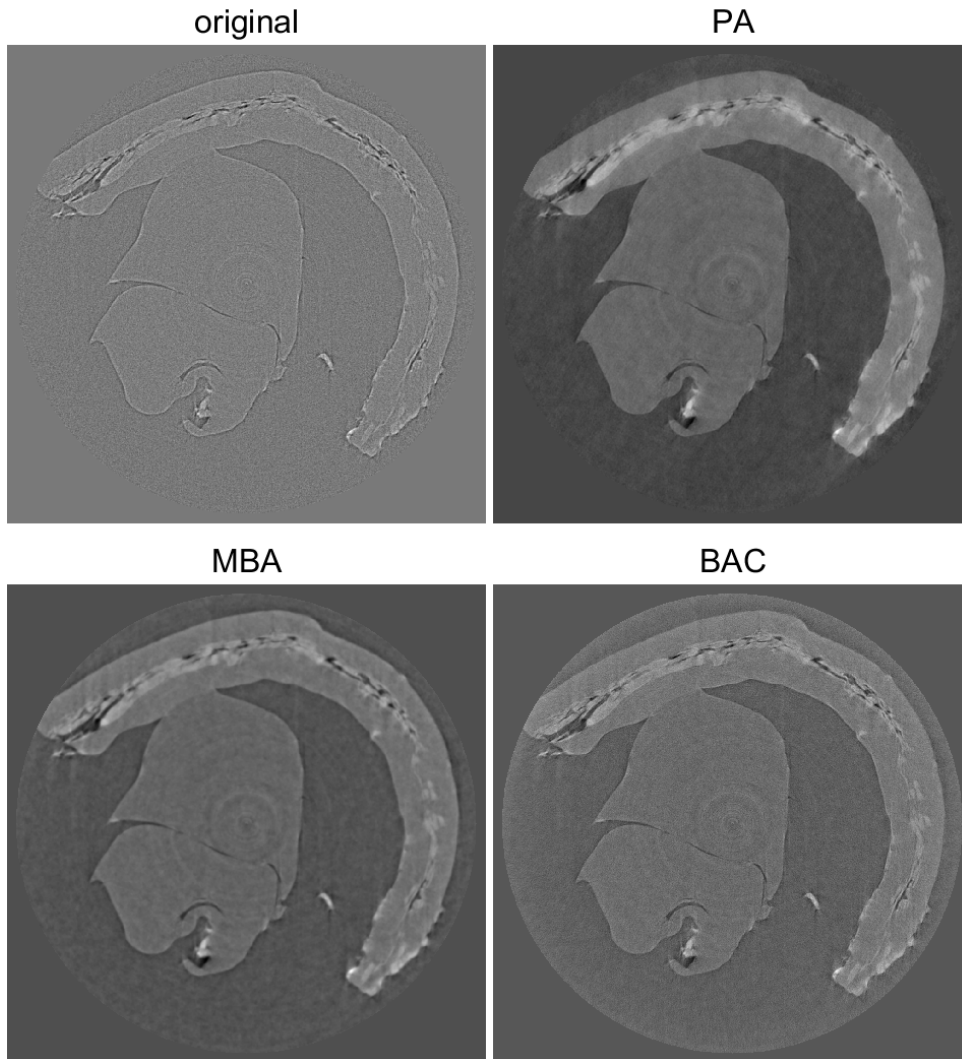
CT slices of PEDT with different phase retrieval algorithms (Paganin algorithm – PA, Modified Bronnikov algorithm – MBA, Bronnikov aided correction – BAC).
